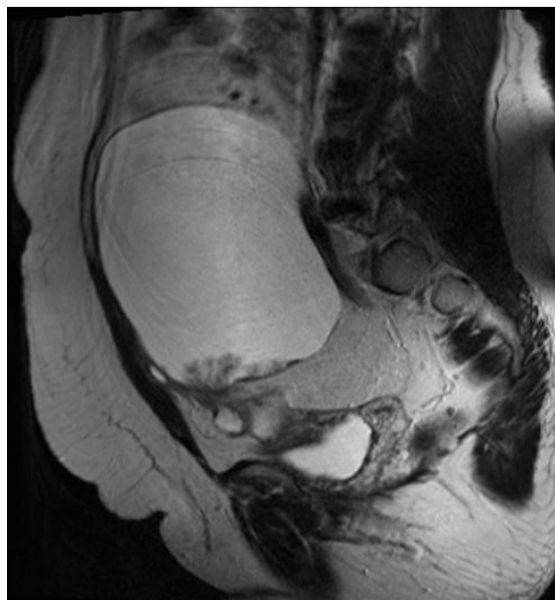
MRI saggital T2 W image of malignant ovarian mass lesion. Showing a large ovarian cystic lesion with papillary projections (Later on proved to be a malignant surface epithelial ovarian carcinoma).
